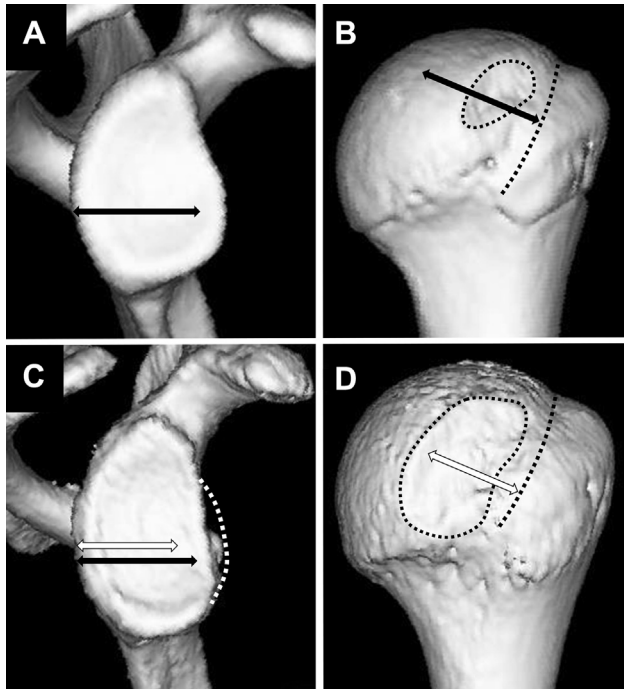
Computed tomography images of patients with on-track (A, B) and off-track (C, D) Hill-Sachs lesions. The black arrows represent the glenoid track width in patients without glenoid defects, which corresponds to 83% of the transverse glenoid width. For patients with glenoid defects, the glenoid track width (white arrows) is obtained by subtracting the glenoid defect width from the value for the black arrows.
